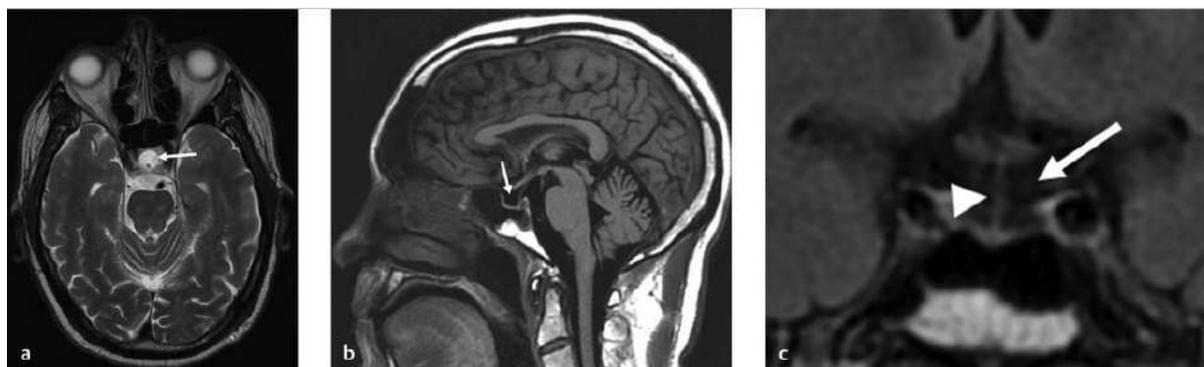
(a-c). Brain MR images without contrast including axial T2-weighted (fig.2-a), sagittal T1-weighted (fig2-b), and coronal fluid-attenuated inversion recovery (FLAIR)(fig2-c) sequences demonstrate an empty sella (white arrows) filled with CSF with nonvisualization of the pituitary gland. However, the pituitary stalk can be visualized (arrow head)
